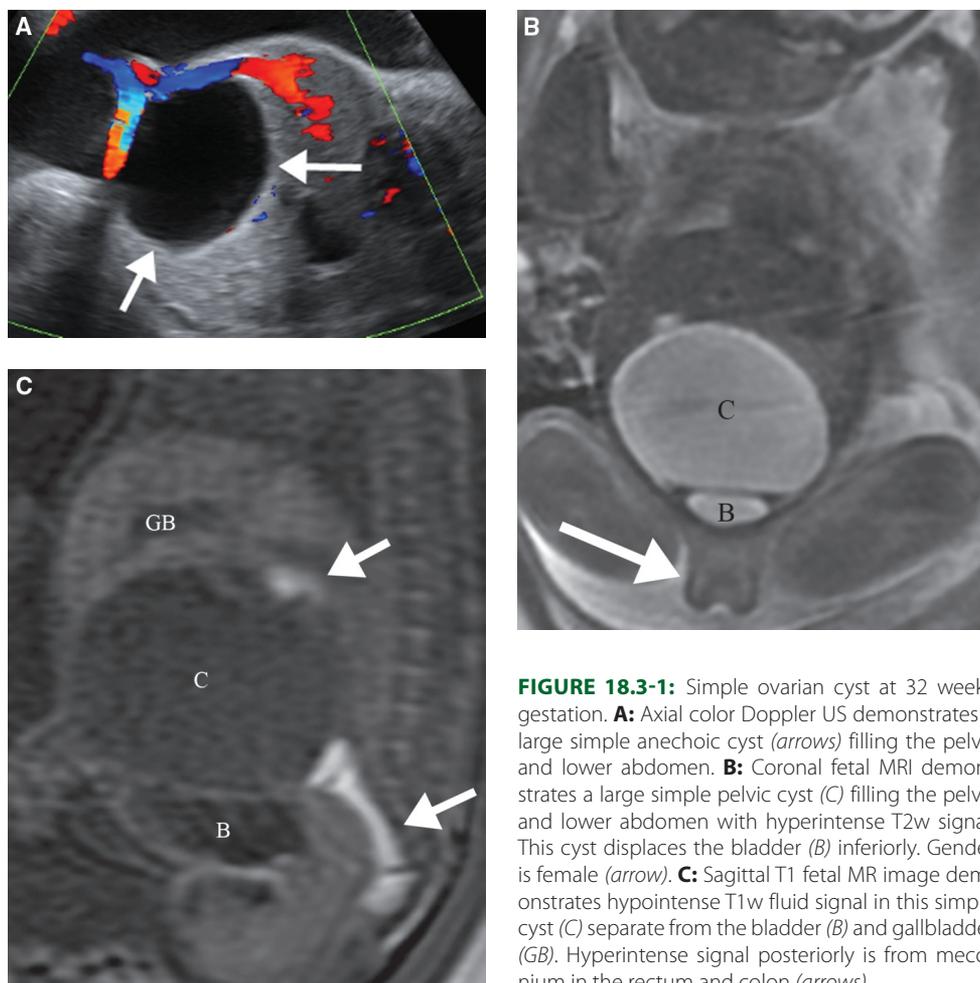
Simple ovarian cyst at 32 weeks' gestation. A: Axial color Doppler US demonstrates a large simple anechoic cyst (arrows) filling the pelvis and lower abdomen. B: Coronal fetal MRI demonstrates a large simple pelvic cyst (C) filling the pelvis and lower abdomen with hyperintense T2w signal. This cyst displaces the bladder (B) inferiorly. Gender is female (arrow). C: Sagittal T1 fetal MR image demonstrates hypointense T1w fluid signal in this simple cyst (C) separate from the bladder (B) and gallbladder (GB). Hyperintense signal posteriorly is from meconium in the rectum and colon (arrows).
